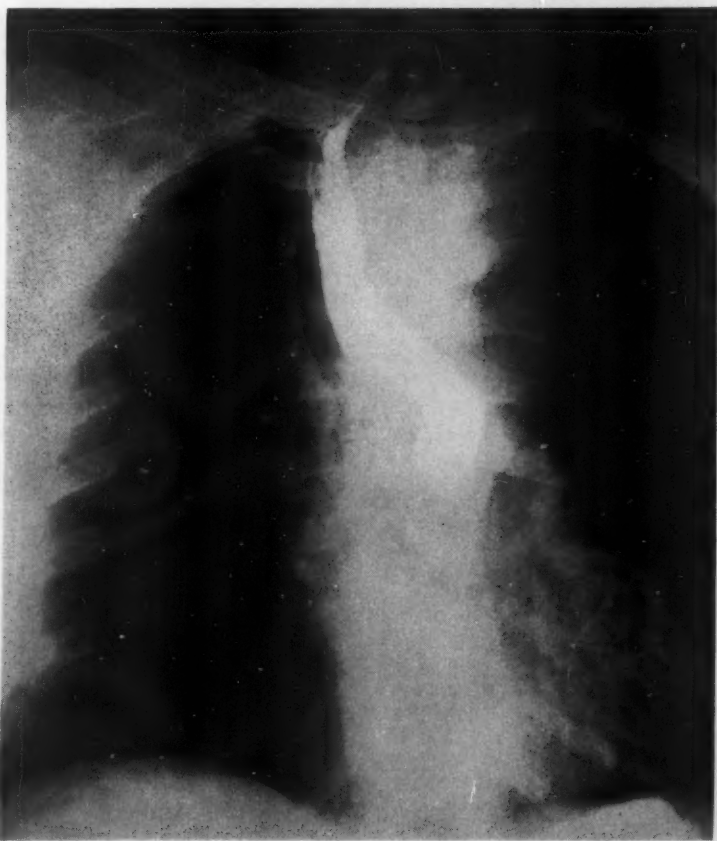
The barium-esophageal roentgenogram of a 62 year old white female who had noted occasional episodes of difficulty in swallowing for the last six years. Within the last six months there had been exertional dyspnea. On physical examination a nodular thyroid was palpated, and a mass which, on swallowing, rose from the retromanubrial space. A radiiodine uptake over the sternal area gave marked activity, which was interpreted as evidence of active intrathoracic thyroid tissue.
